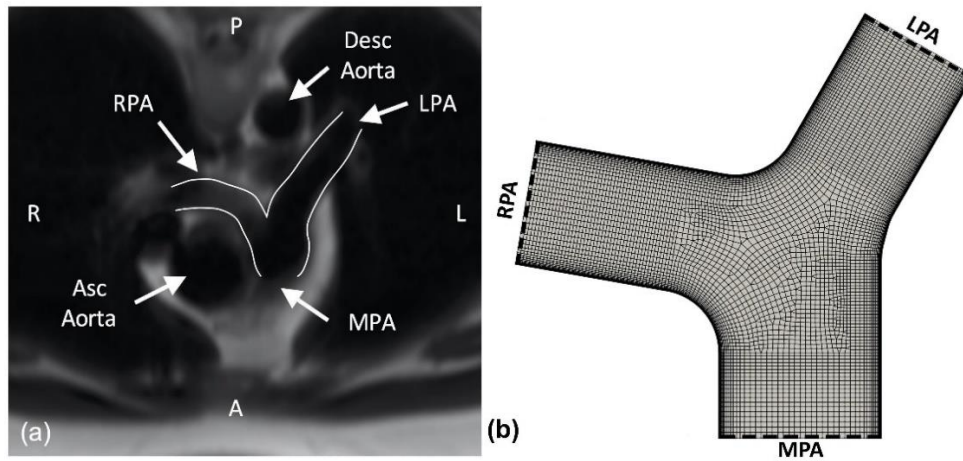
(a) An axial black-blood MRI image from a healthy male volunteer (27 years old), overlaid with an outline of the inner and outer walls of the pulmonary bifurcation. (b) Computational mesh for the geometry of Fig. 3.1 (ii), consisting mainly of quadrilateral elements, a few triangular elements in the middle of the bifurcation and a boundary layer near the wall.
